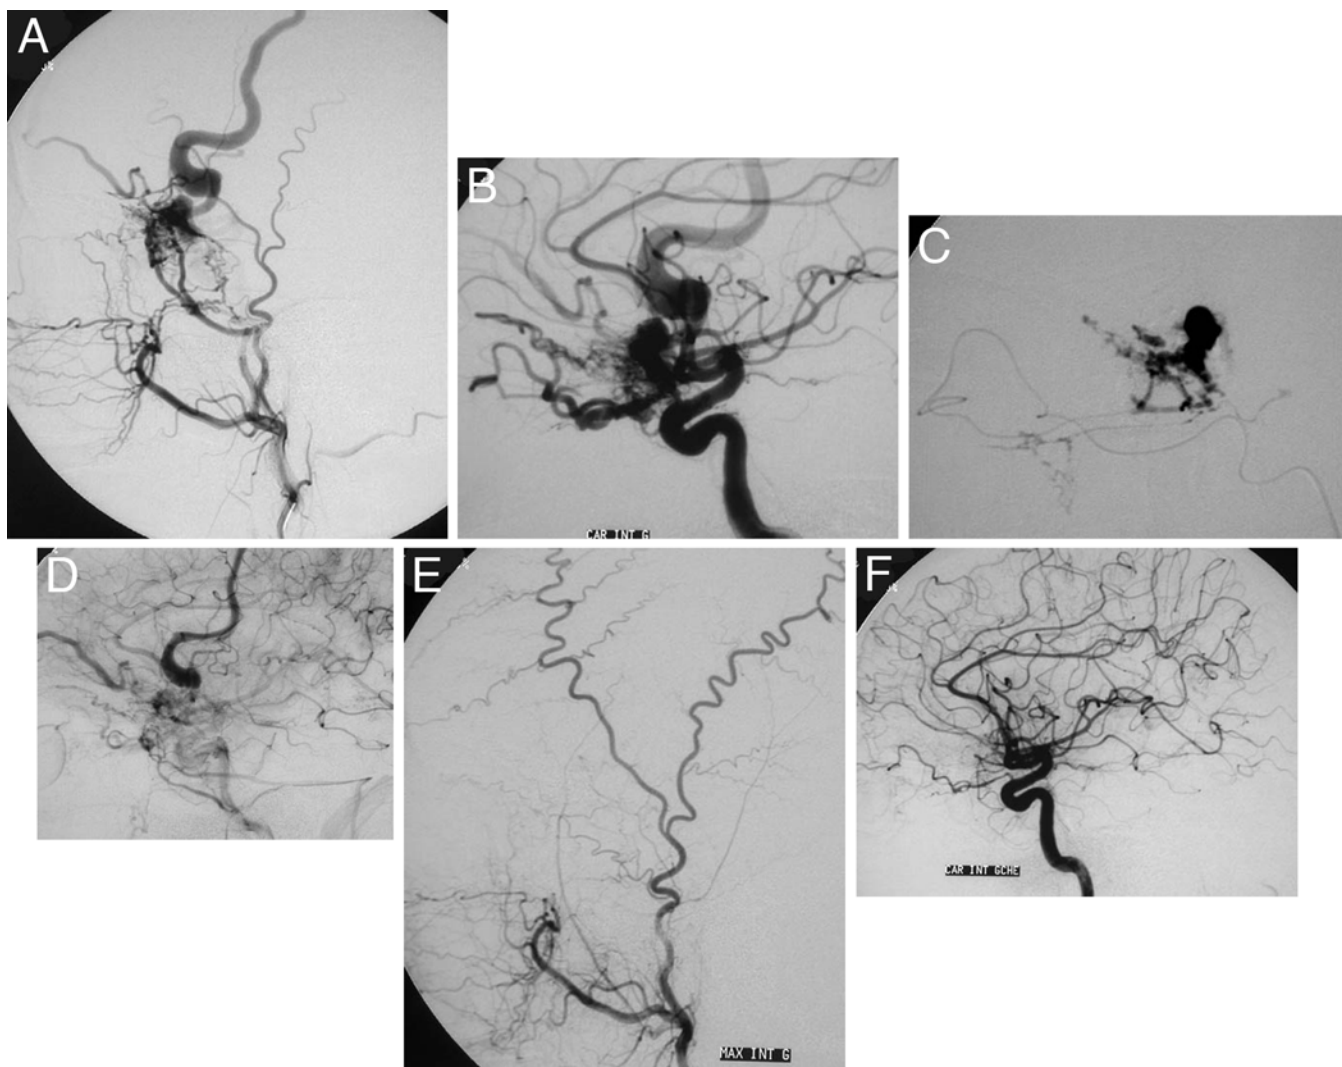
Angiograms obtained in a 61-year-old man who presented with headaches and an episode of nonspecific discomfort and in whom MR imaging revealed a suspected vascular malformation in the sphenoid region. A and B: Lateral views after injection of the left internal maxillary artery (A) and ICA (B) revealed a dural shunt located at the level of the sphenoid ridge and draining into 2 cortical frontal veins, which drained into the superior sagittal sinus. A first injection of glue via the middle meningeal artery failed to penetrate properly into the proximal portion of the draining vein because of lack of wedge catheterization. C: Image obtained after a second injection of glue (during the same session) into the recurrent branch of the OA, showing the casting of the remaining portion of the nidus and penetration into the foot of the main cortical vein. D: Immediate postoperative angiogram obtained after left ICA injection showing persistent, although reduced, flow in the shunt. Because of adequate reduction of flow, no further embolization was performed. E and F: Internal maxillary artery (E) and ICA (F) injection angiograms obtained 3 months after treatment, confirming secondary thrombosis of the shunt and cure of the ICDAVS. The patient returned to normal life without any complaints.
